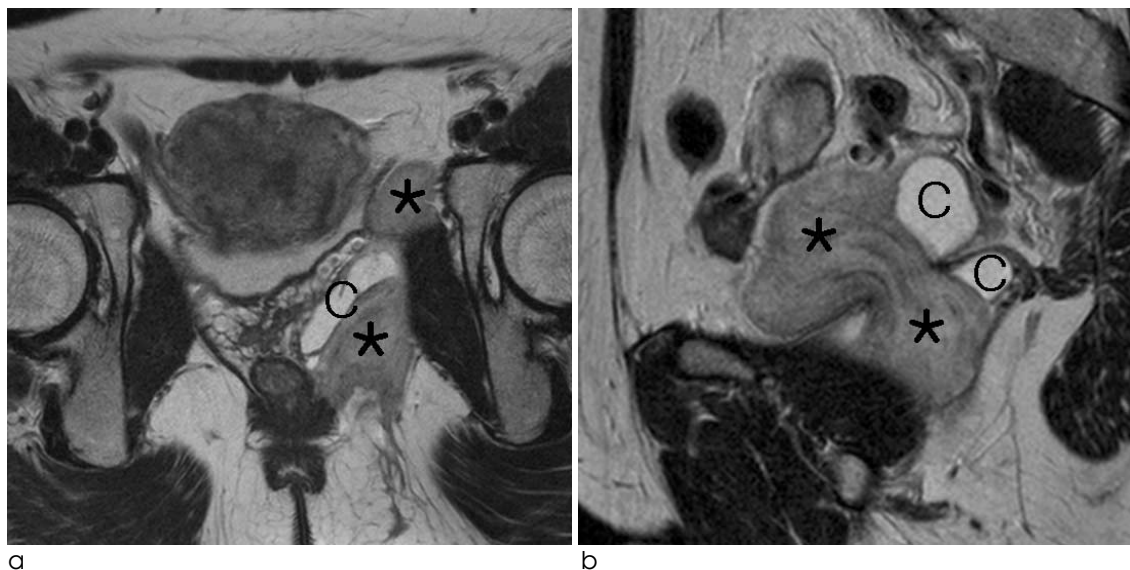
A 44-year-old female with aggressive angiomyxoma extending from vulva to pelvis. a, b. T2-weighted FSE imaging (TR/TE = 2,887/80). a. Oblique axial image (asterisks) shows a solid and cystic mass arising from the left ischio-rectal fossa displacing the rectum. b. Sagittal image shows the tumor with swirling strands. C = cystic areas within the mass.
